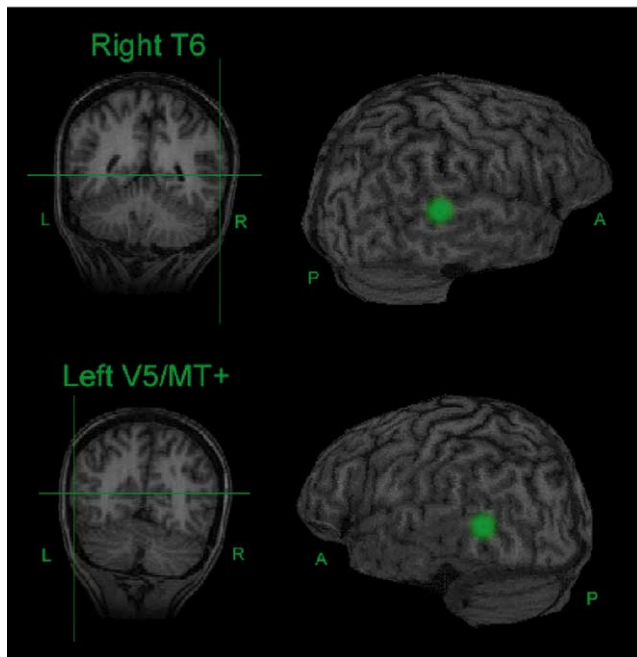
Coronal and whole-brain visualization of stimulation sites. Two participants (author EG shown) provided high resolution anatomical MRI images which were co-registered with the stimulation device. Cross-hairs on coronal image indicate focus of the projected stimulation path as shown on the whole-brain image.
